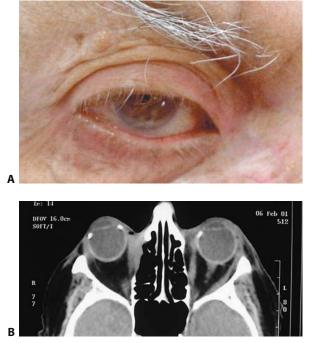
(A) A 72-year-old Caucasian male whose medial canthal basal cell carcinoma had been treated with radiotherapy 10 years earlier. The patient re-presented with limitation of movement and a mass in the medial orbit. (B) The CT scan of the patient shows the mass extending down the medial orbital wall.
